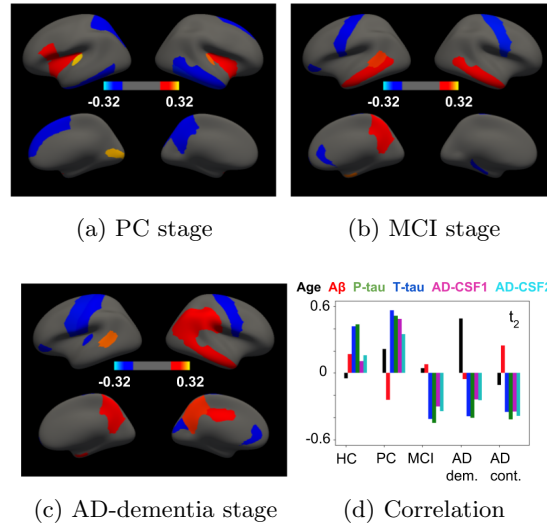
AD-related effect-type of the brain latent model using cortical thickness features. It corresponds to the third latent dimension of the model t_2^{CT} at each stage of the Alzheimer’s continuum. The effect size at each disease stage is shown on the bottom-right.
